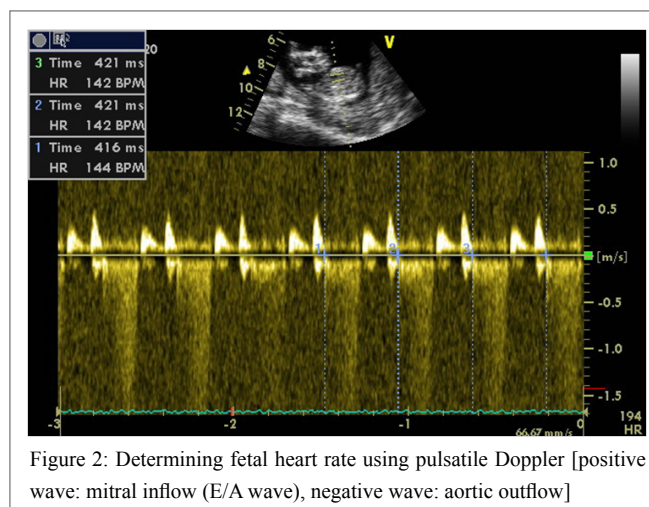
Determining fetal heart rate using pulsatile Doppler [positive wave: mitral inflow (E/A wave), negative wave: aortic outflow]
